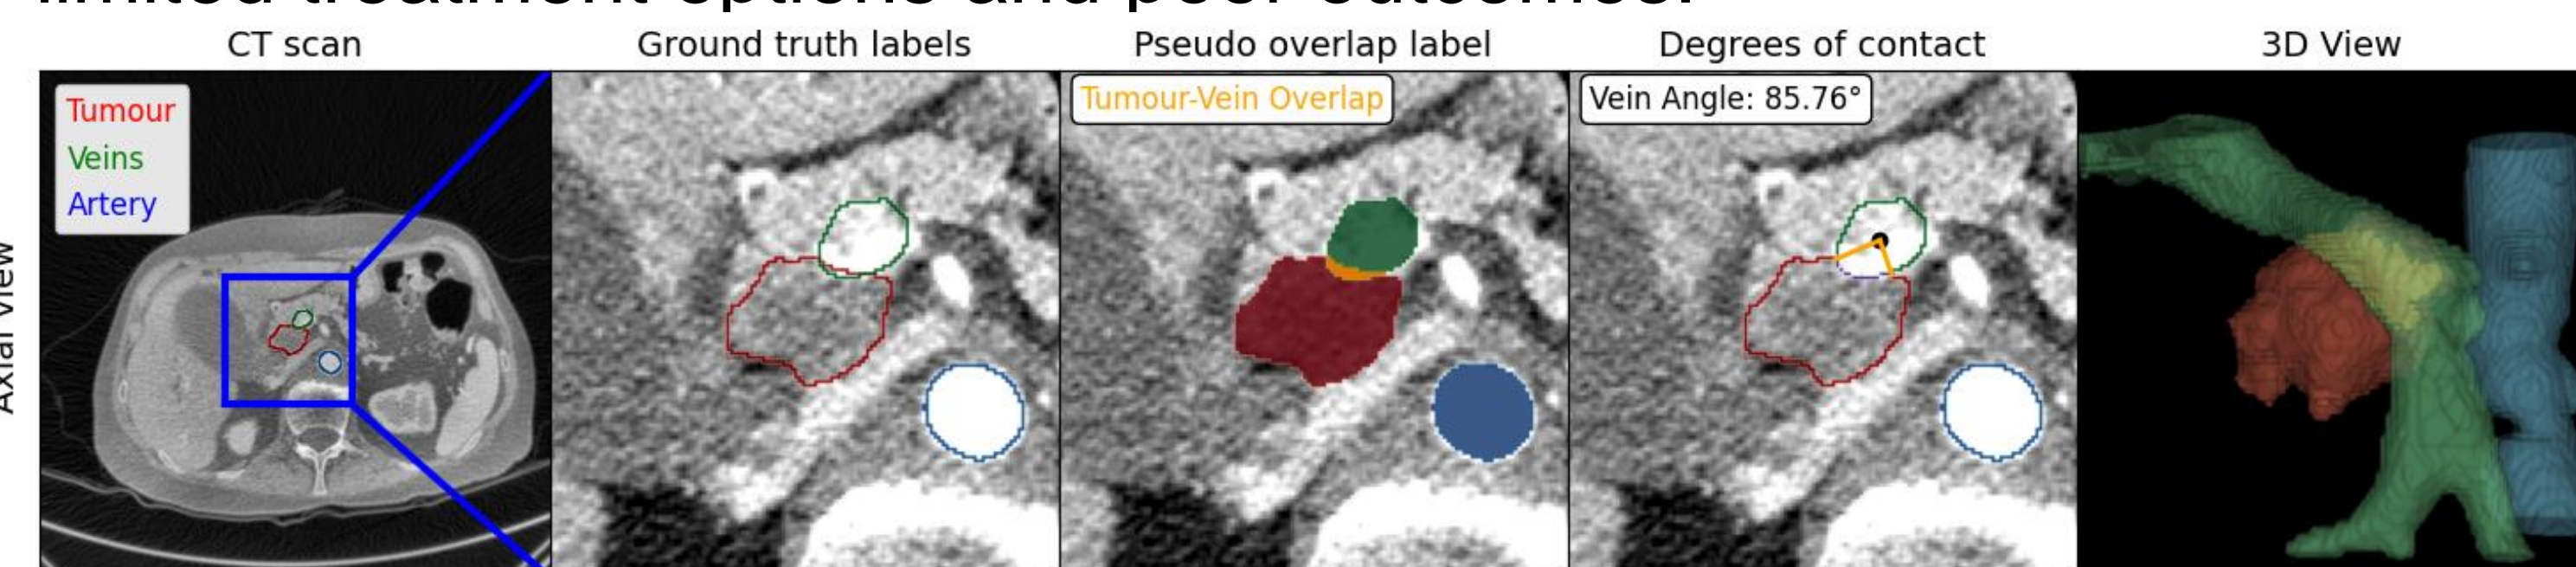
Slice from CT scan depicting the involvement.
